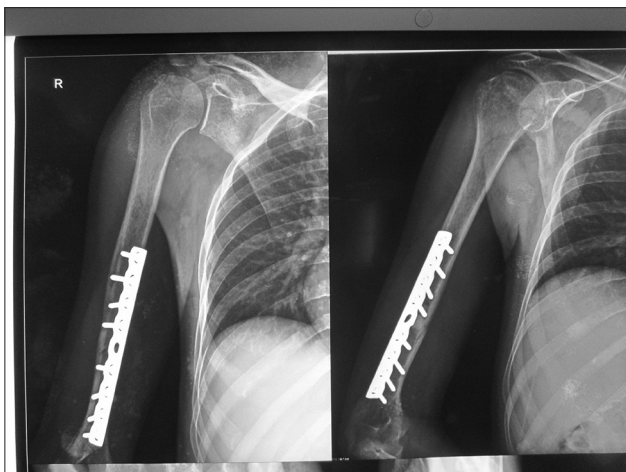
Plain radiographs anteroposterior view of the right arm and shoulder showing posterior shoulder dislocation with greater tuberosity fracture with fracture shaft humerus
